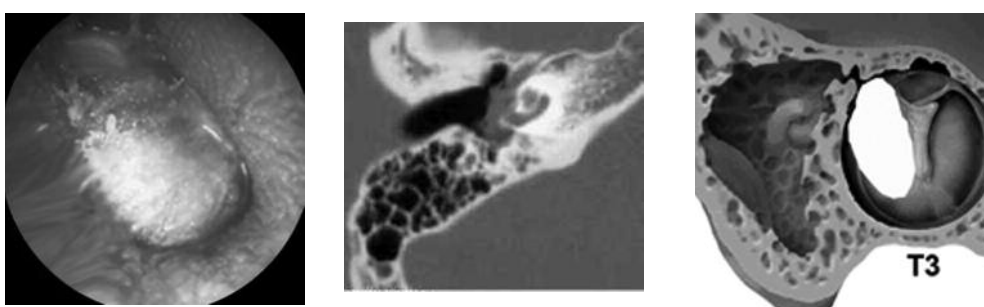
Otoloscopic and CT findings of case 2.
